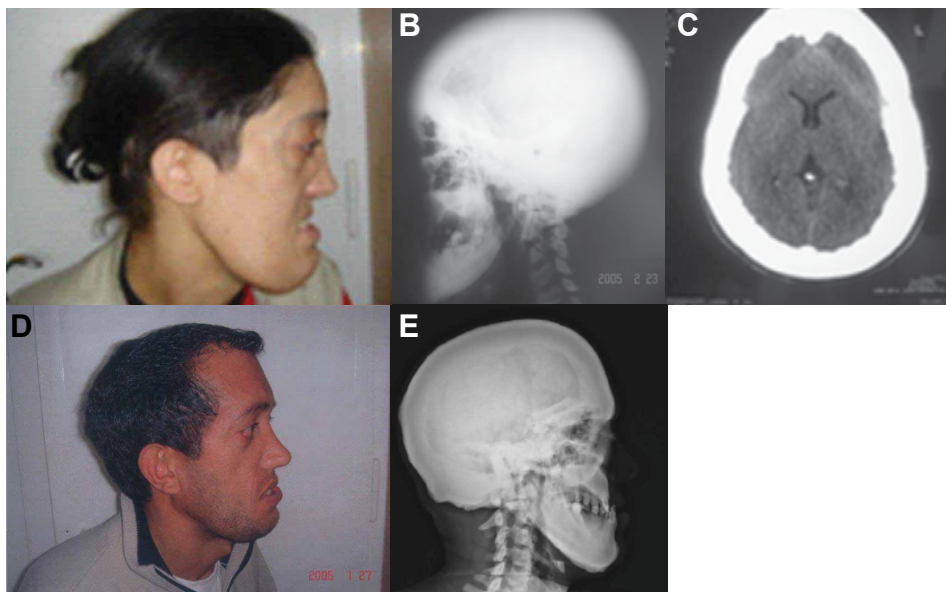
A) Lateral view of the female patient's face showing a marked mandibular prognathism. B) Plain radiograph of the skull (lateral view) showing uniform sclerosis of the calvaria, skull base and facial bones (particularly the mandible). C) Axial CT-scan of the brain showing marked thickening of the cranial vault. D) Lateral view of the face of the female's brother, who also shows a marked mandibular prognathism. E) Plain radiograph of the skull (lateral view) of the brother, showing uniform sclerosis of the skull and the mandible.
